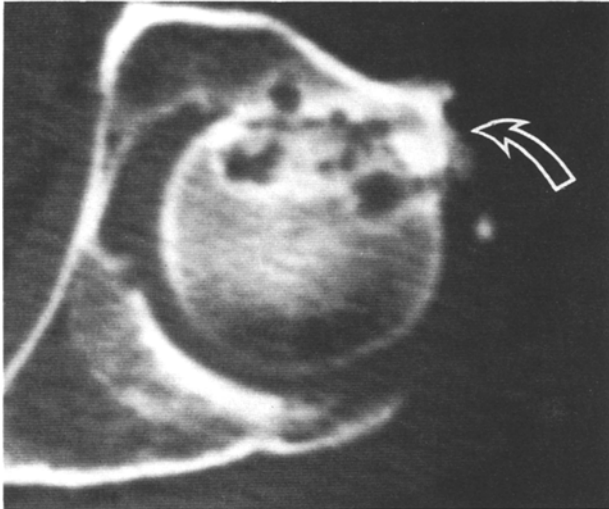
Osteoarthritis. Axial CT image of the left hip demonstrates anterior migration of the femoral head relative to the acetabulum, related to the localisation of typical degenerative changes including joint space loss, subchondral cysts, and sclerosis (*arrow*)
